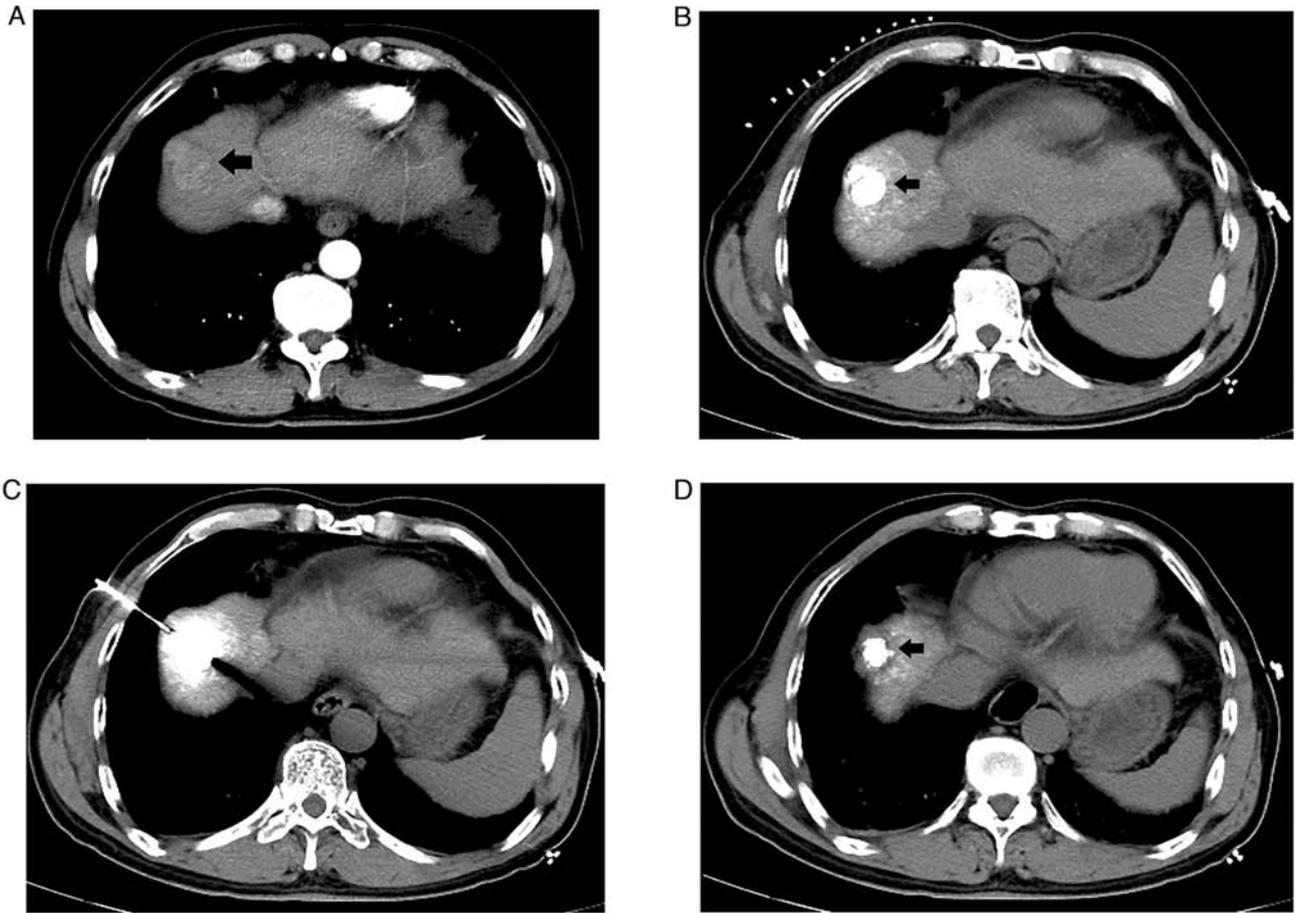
(A) Arterial phase axial CT image indicated a round-like mass measuring $\sim 3.0 \times 2.5$ cm (arrow) in hepatic segment VIII, abutting the diaphragm. (B) After trans-arterial chemoembolization, the accumulation of iodized oil in the hepatic tumor area was confirmed (arrow). (C) Axial CT image confirming the final position of the MWA antenna tip in the center of the hepatic tumor. (D) Abdominal CT immediately after MWA indicates that the ablation zone (arrow) has adequately subsumed the tumor. MWA, microwave ablation.
